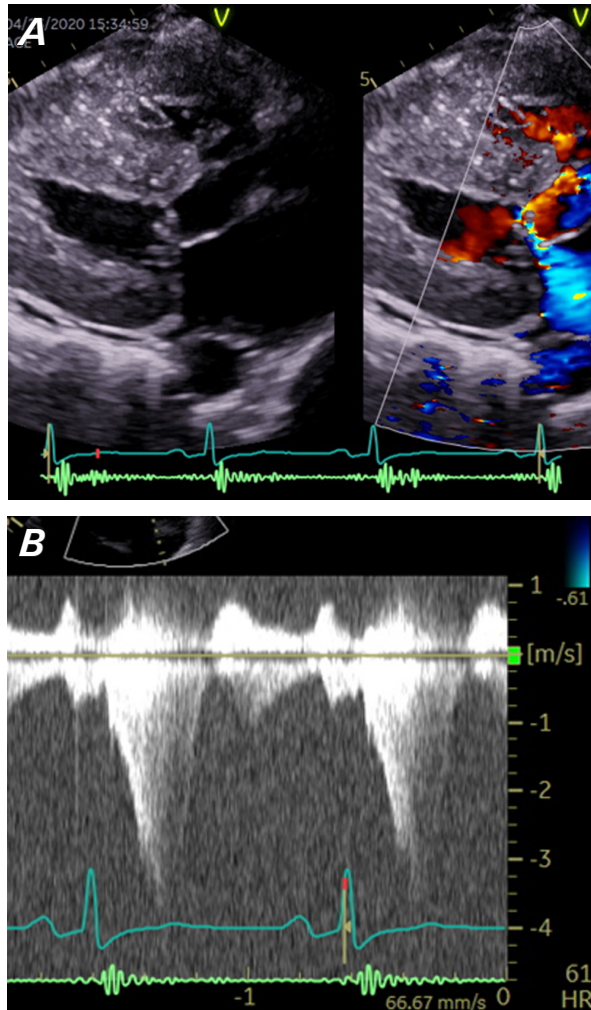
A) Parasternal long-axis view shows mitral regurgitation resulting from systolic anterior motion of the mitral valve. B) Significant left ventricular outflow tract obstruction is shown.
